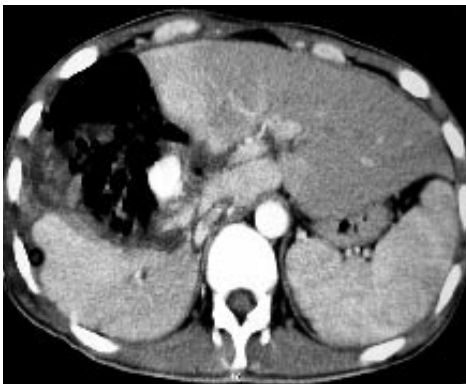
Axial contrast-enhanced CT scan revealing a vascular mass lesion in the right lobe of liver.
